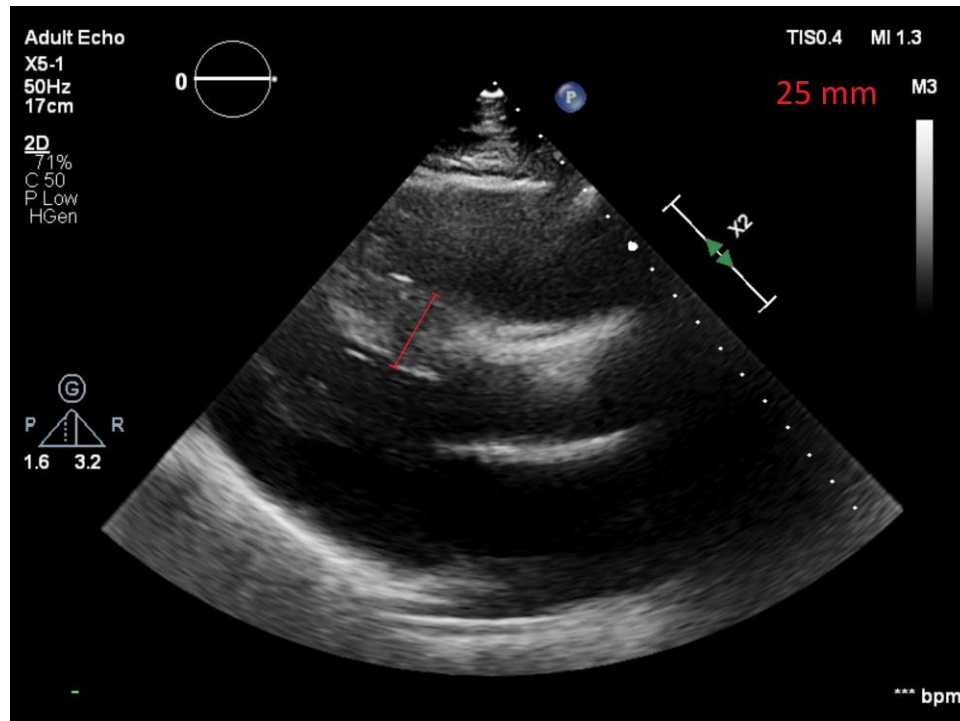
Transthoracic echocardiography—parasternal long axis view. Maximum interventricular septum thickness.
